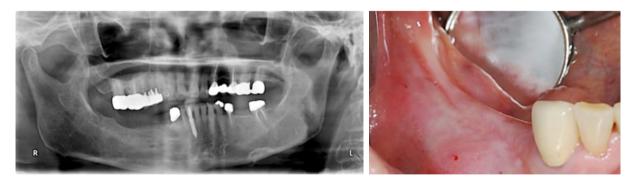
~2. Pre-operative radiograph & Intra-oral view.
